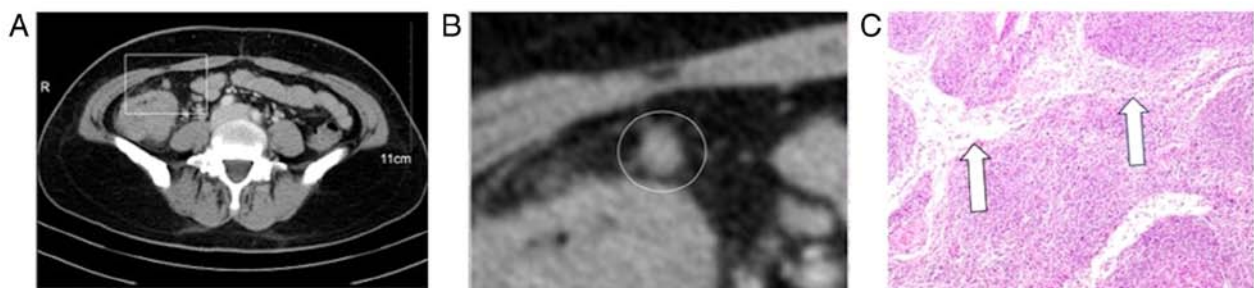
Stripe enhancement characteristics. (A) Contrast-enhanced CT scan images in the equilibrium phase with colon cancer in the ileocecum. (B) A lymph node with stripe enhancement characteristics. (C) The white arrow indicates the interlinked capsular sinus of the lymph node.
